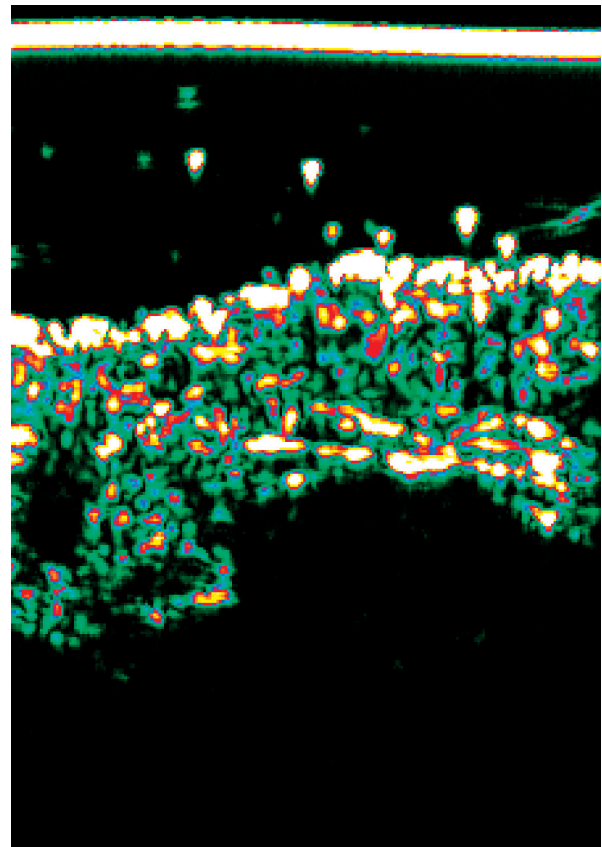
Ultrasound scan after UVA1 irradiation
